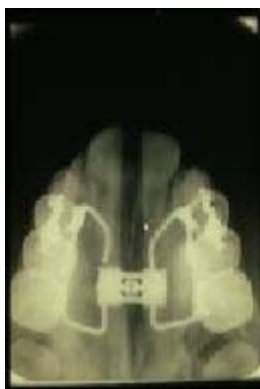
Palatal radiograph of rapid palatal expansion after one week of treatment.
